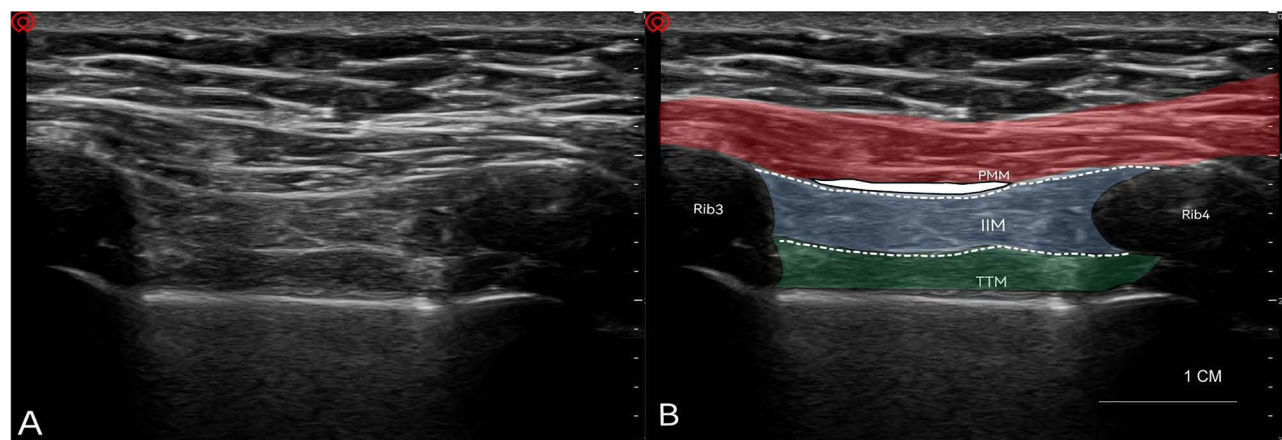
Parasagittal parasternal ultrasound image. (A) Pre-annotation; (B) Post-annotation. The in-plane view demonstrates the parasternal intercostal block plane between the third and fourth ribs. A 1-cm scale bar is included for depth calibration. PMM, Pectoralis Major Muscle (red overlay); IICM, Internal Intercostal Muscle (blue overlay); TTM, Transversus Thoracis Muscle (green overlay). White dashed lines indicate target fascial layers for blockade. SPIP, Superficial Parasternal Intercostal Plane Block (upper dashed line, injection site); DPIP, Deep Parasternal Intercostal Plane Block (lower dashed line, injection site).
